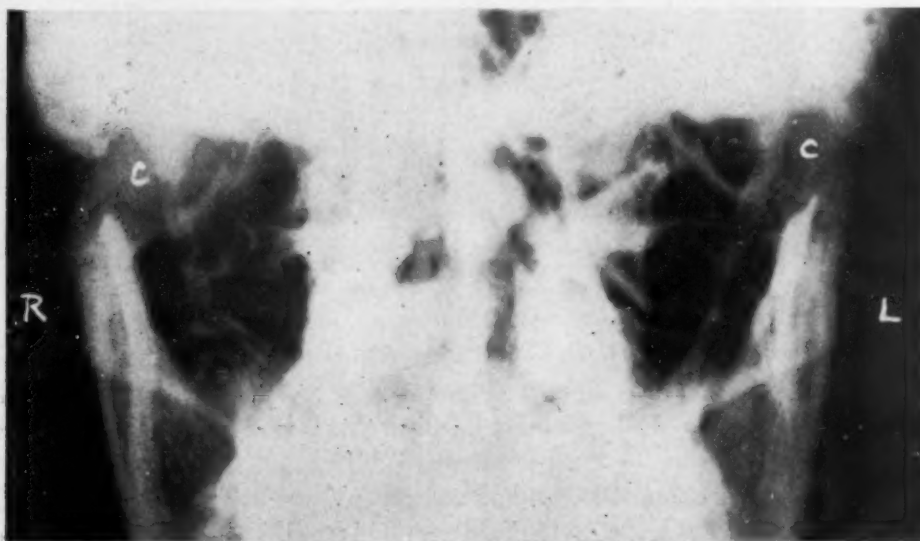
Postreduction x-ray showing on the right an unreduced dislocation; on the left a reduced dislocation of the condyles (C).
